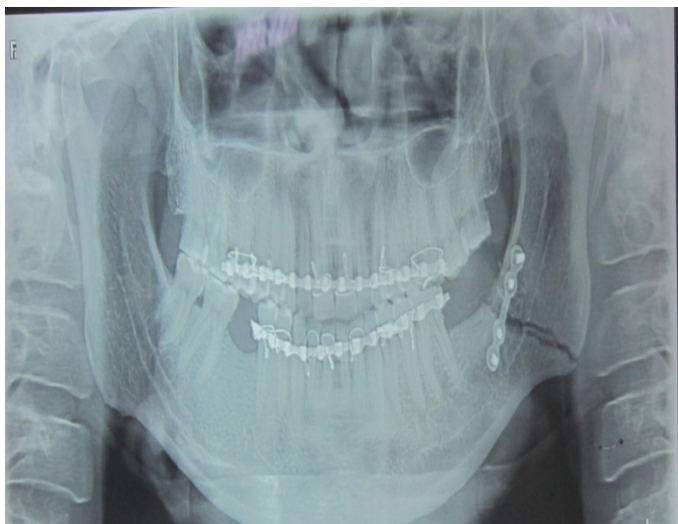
Post Operative Orthopantomogram showing plate in position
